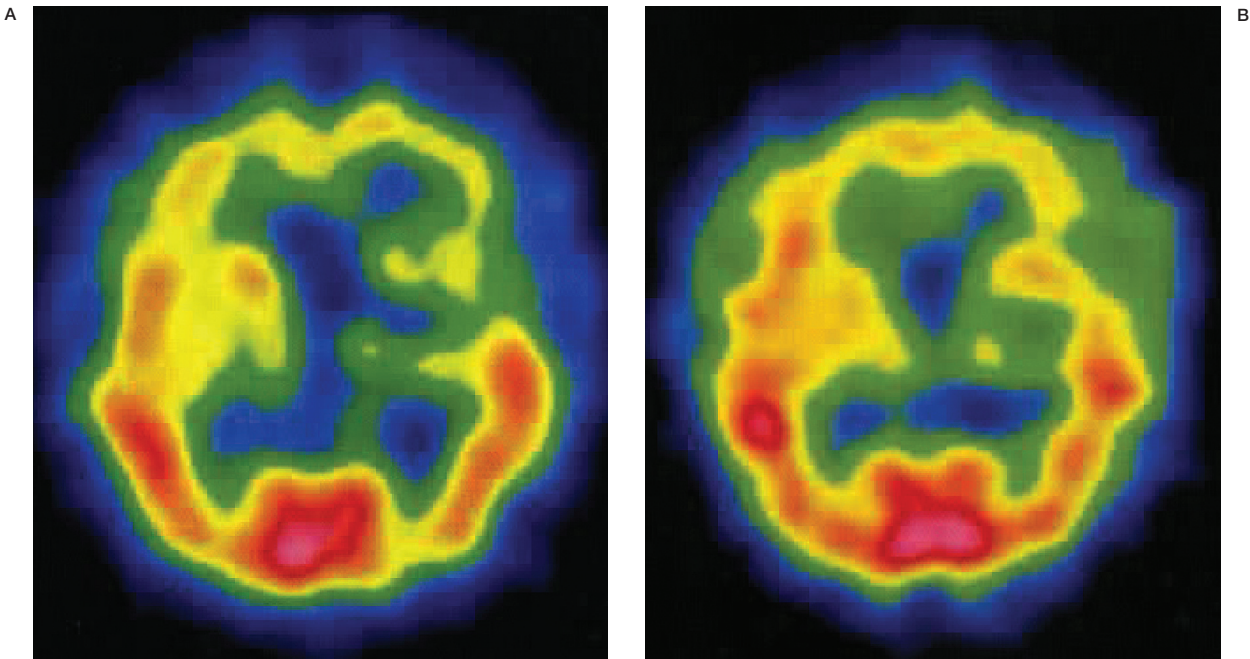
Single-photon emission computed tomography obtained before endovascular treatment (A) and after treatment (B).
